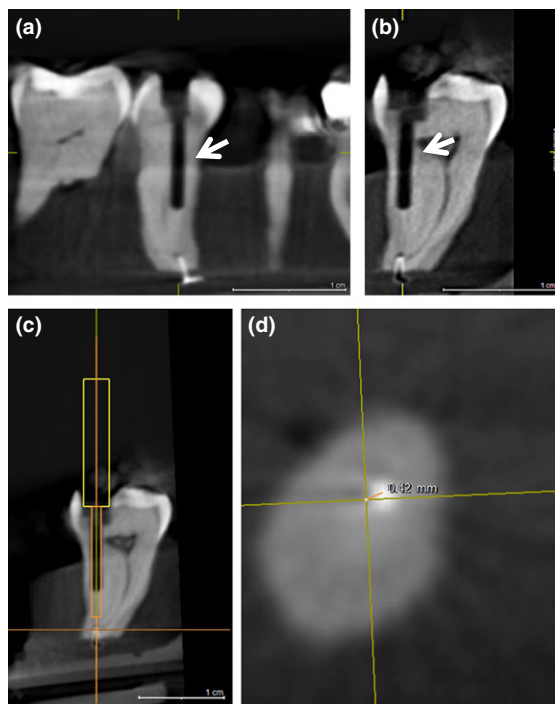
The CBCT scan of the test block after guided drill path preparation: (a) tangential (b) cross-sectional. A virtual drill path is superimposed on the performed drilling path: (c) cross-sectional. The distance between the axis of the drill path and the centre of the target point can be measured on the axial view. The distance was in this example 0.42 mm: (d) axial detail.
